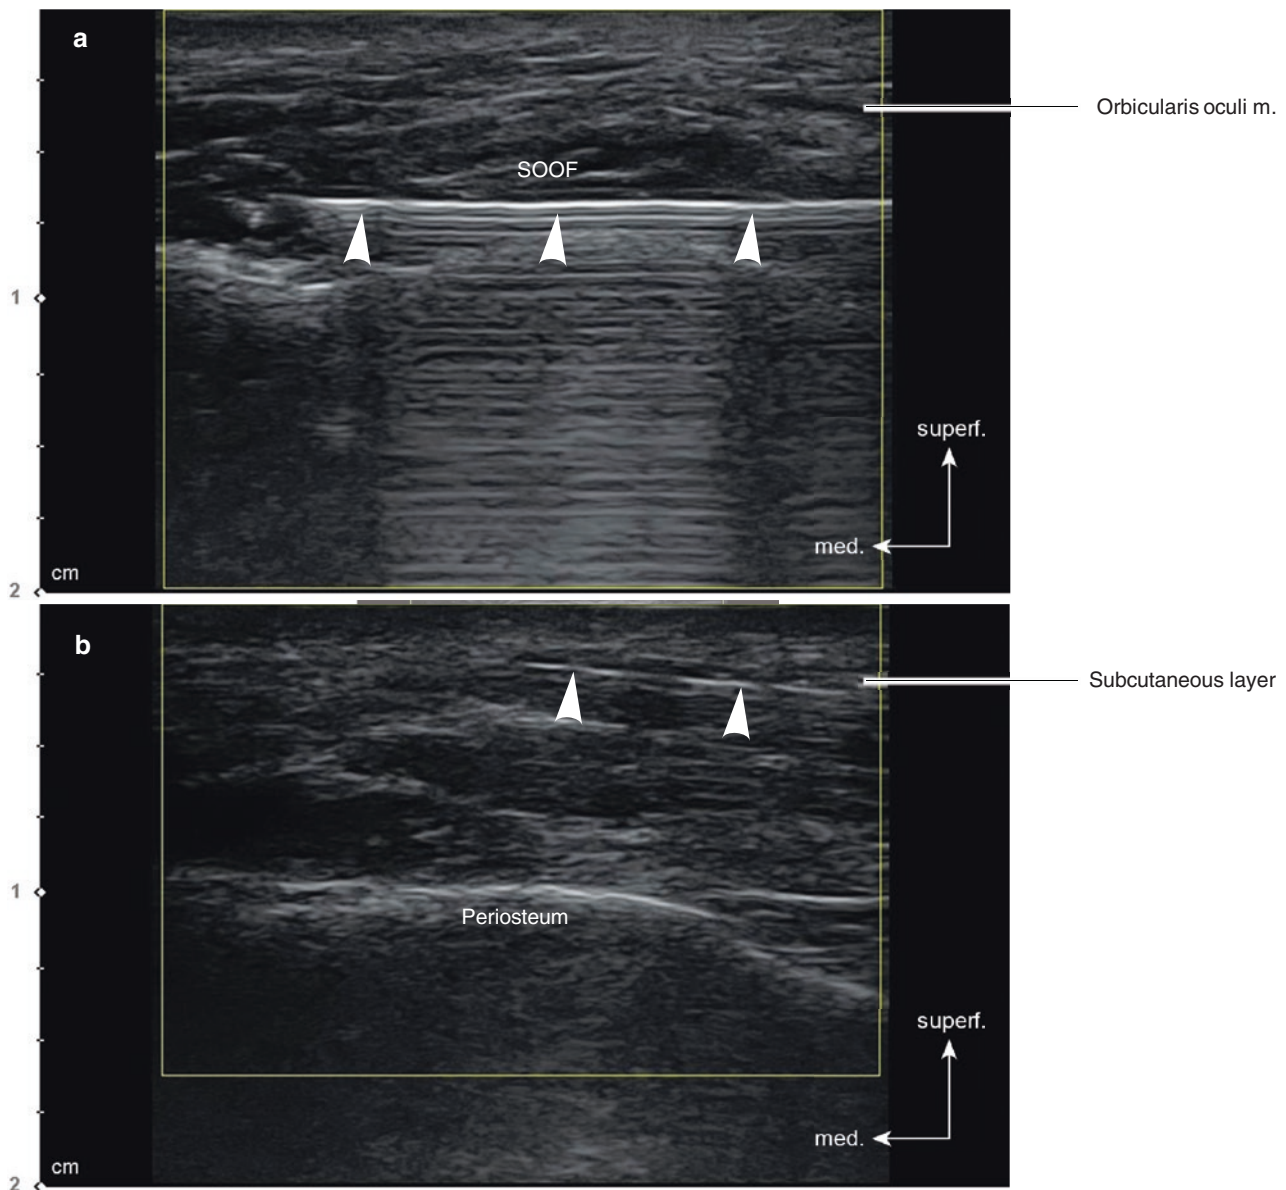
Ultrasonography-guided HA filler injection for the tear trough augmentation. (a) Deep injection, B mode (transverse view, 15 MHz by linear transducer) and (b) superficial injection, B mode (transverse
